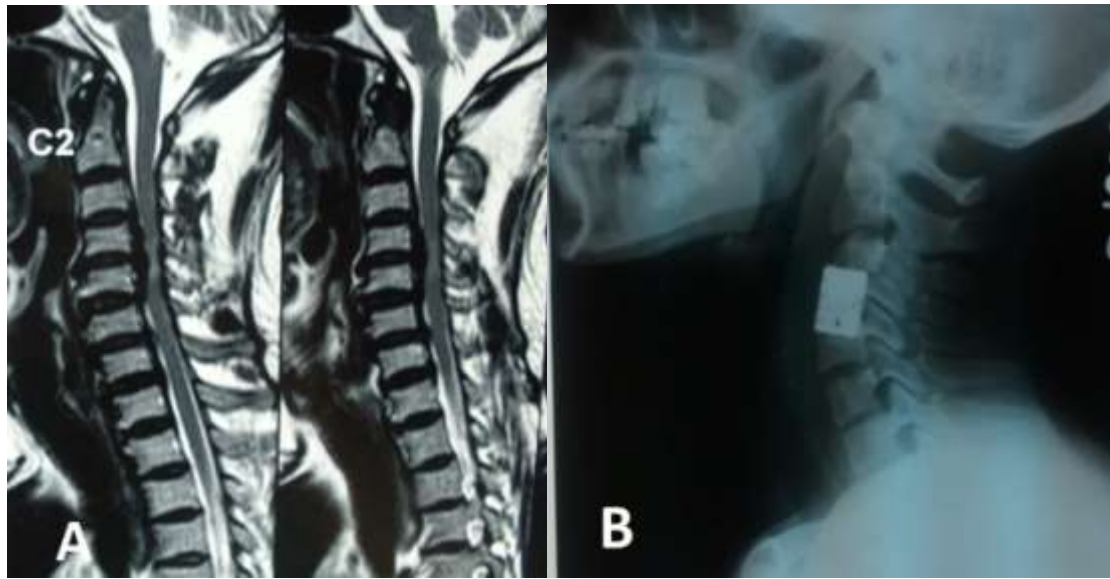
Pre-operative MRI (A) and Post-operative (B) radiograph images of a 62 years old patient with cervical myelopathy who underwent C4-corpectomy with standalone cage fusion.
